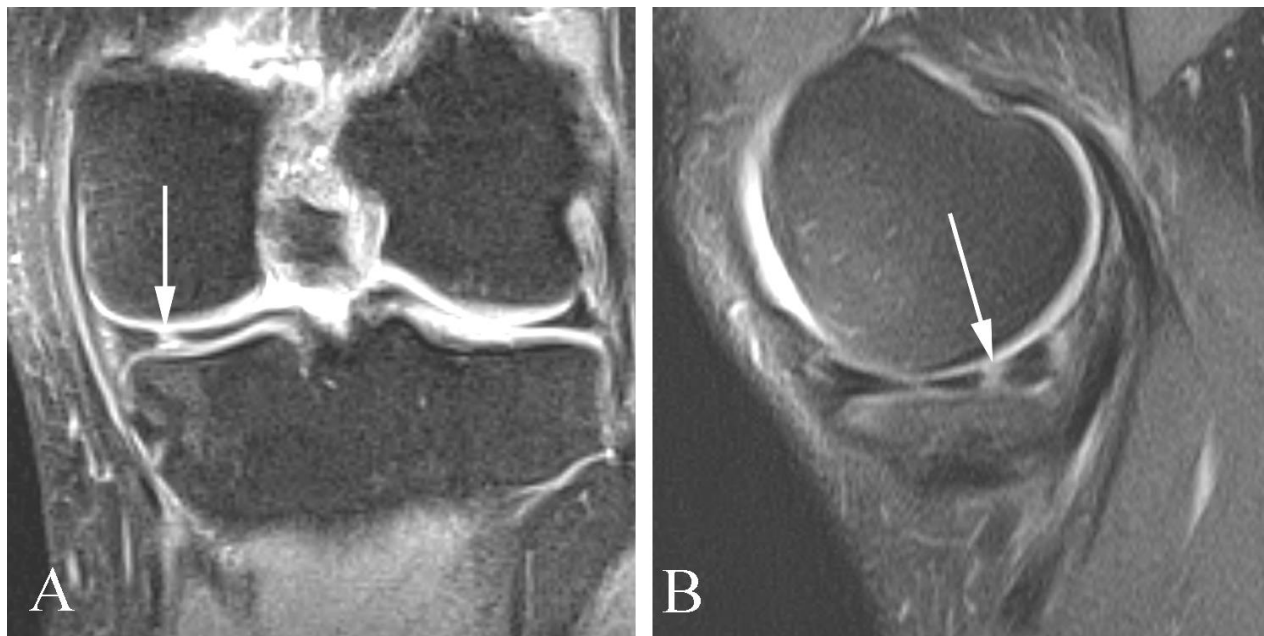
Meniscal tear in a 63 year old man with chronic knee pain. A. Coronal fat-suppressed proton density MR image shows a focal abnormality along the posterior horn of the medial meniscus (arrow). B. Sagittal fat-suppressed T2 weighted image (arrow) shows increased signal intensity extending through the meniscus from the femoral side to the tibial side (arrow), compatible with a full thickness meniscal tear.
